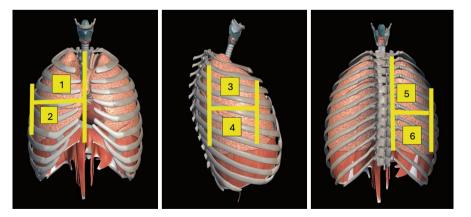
The Lung Ultrasound Score (LUS) protocol scores each of the six examined lung regions based on their aeration in each hemithorax
